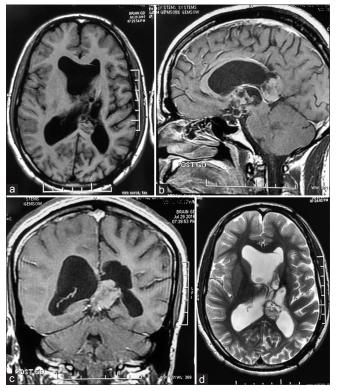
Contrast-enhanced magnetic resonance imaging showing increased residual tumor size in (a) T1-weighted (axial view), (b) T1-weighted (sagittal view; postcontrast), (c) T1-weighted (coronal view; post contrast), (d) T2-weighted (axial view) images
